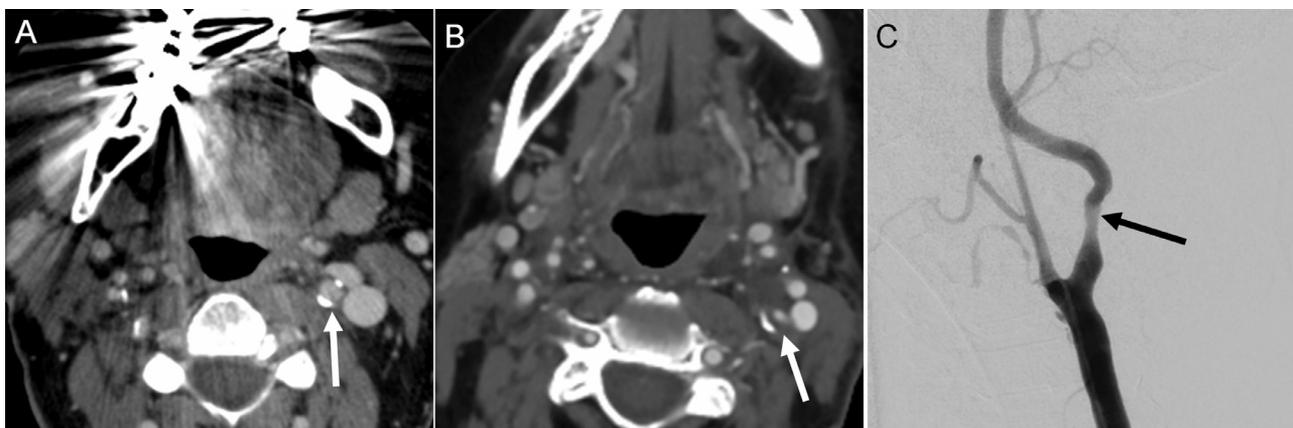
A 56-year-old initially diagnosed with a T2N0 squamous cell cancer of the oral cavity treated with surgery and chemoradiation presents for follow up. An axial CT scan of the neck at diagnosis (A) shows mild atherosclerosis of the left internal carotid artery (A, arrow). At a subsequent follow up 2 years following treatment (B), there is focal narrowing of the left internal carotid artery related to accelerated atherosclerosis (B, arrow). This finding was confirmed at digital subtraction angiography (C, arrow).
